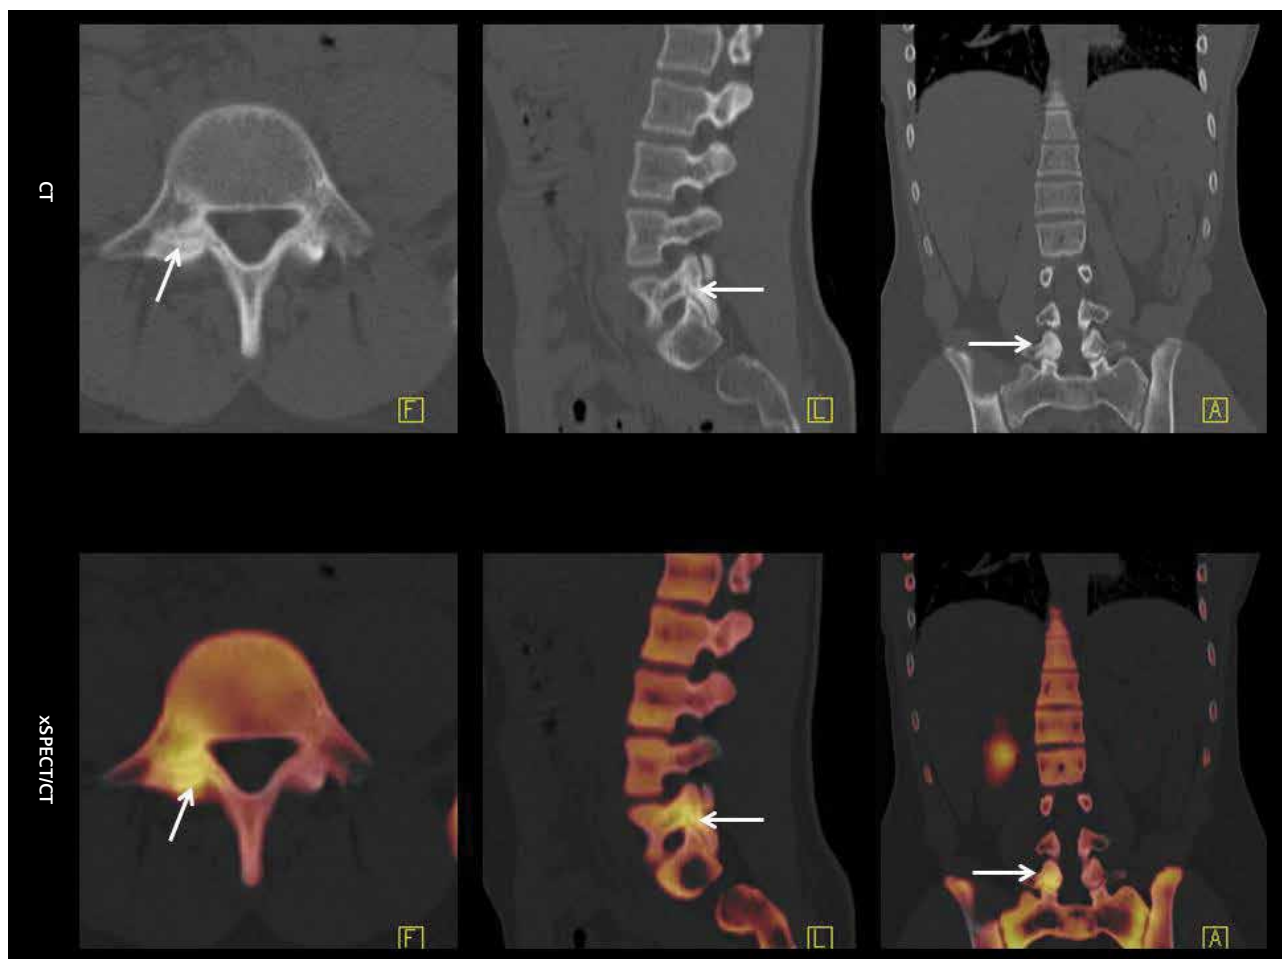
CT shows slightly hypodense transverse fracture line through the pars interarticularis in the right side of the L5 vertebrae (arrows) with surrounding reactive sclerosis. Corresponding images with xSPECT Bone and CT fusions show focal skeletal hypermetabolism exactly localized to the transverse fracture line and adjacent sclerosis in the right pars interarticularis, which suggests a stress fracture related to lumbar spondylolysis.
